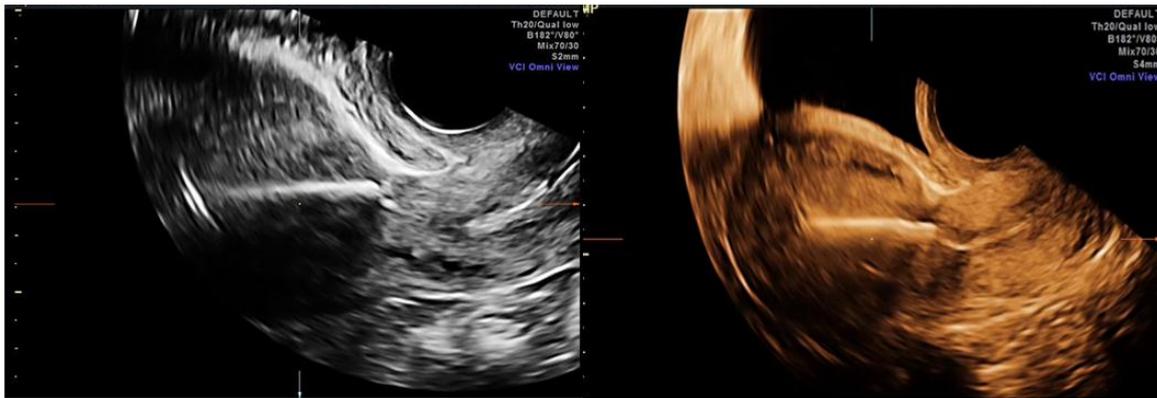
omniview VCI sonographic images for a two cases with previous CS showing no evidence of IUCD penetration to the scar.
